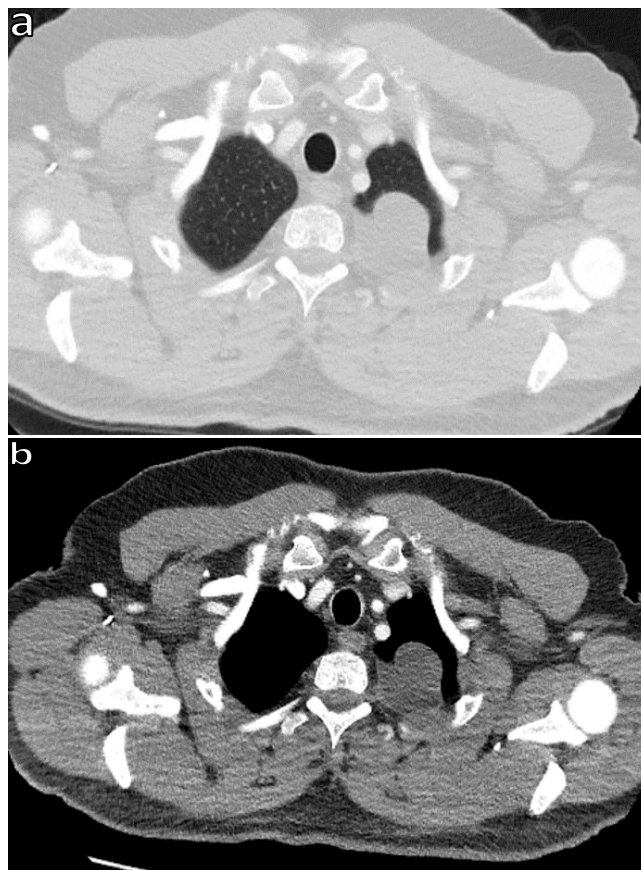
Thoracic computed tomography revealing a mass associated with the medulla spinalis in the upper lobe of the left lung
